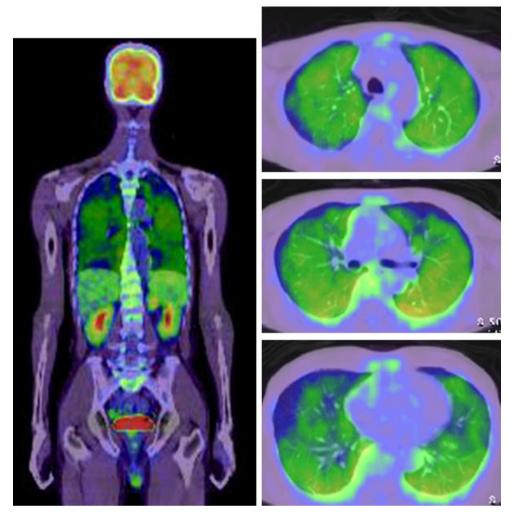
¹⁸FDG-PET/CT findings just prior to admission in September 2008. Increased diffuse FDG uptake, fairly homogeneous from the basal region to the apical region of the lung, was noted bilaterally.
